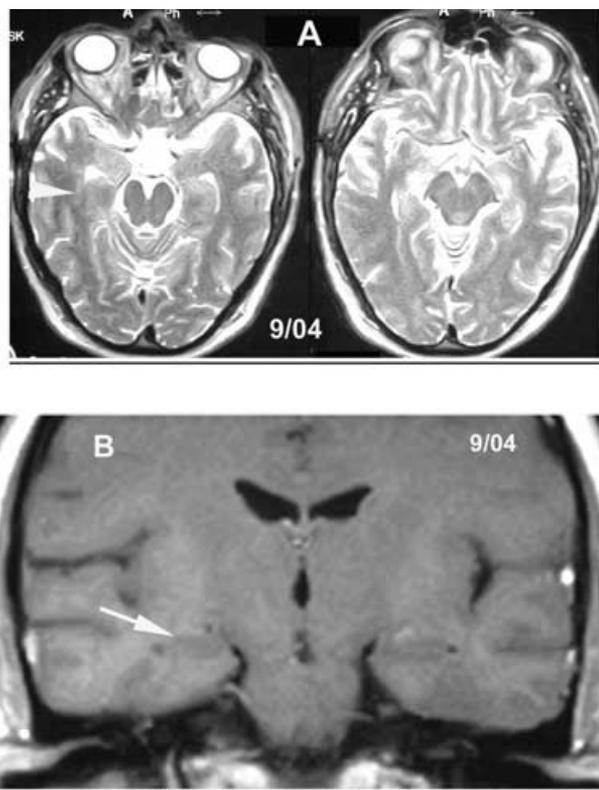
Postoperative brain MRI of Patient 2. A) Axial T₂-weighted images revealing complete normalization of the right hippocampus, also seen on B) Coronal T₁-weighted post-gadolinium image.
